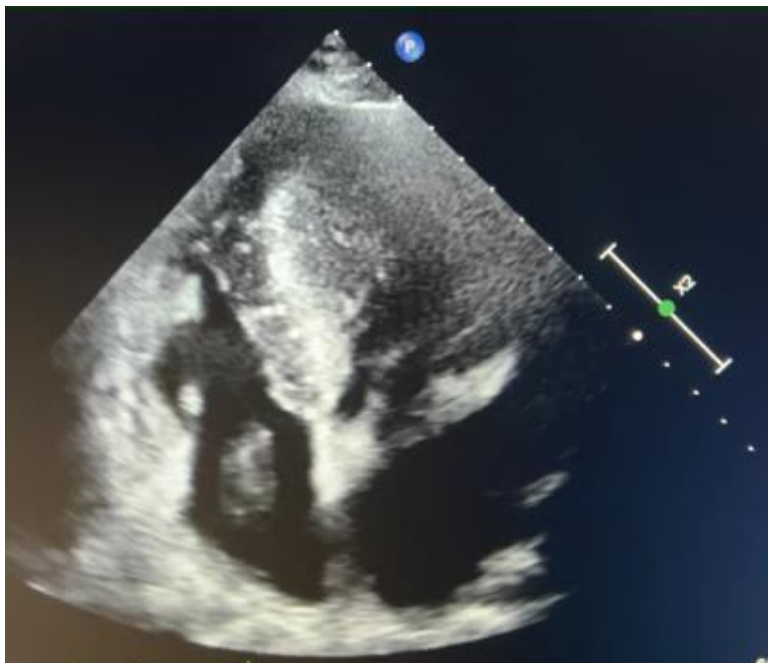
Four-chamber echocardiographic section showing right atrial thrombus
